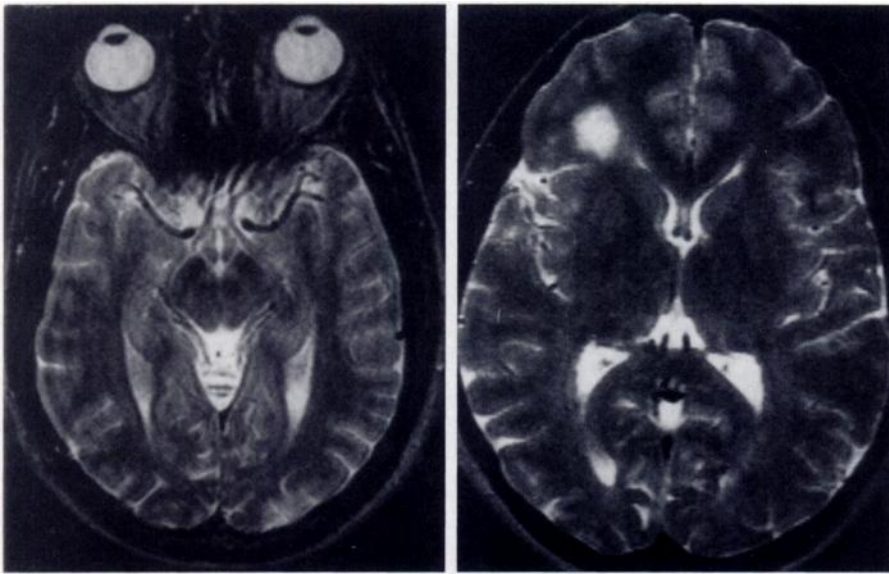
GRASE MR images obtained in the head with NSA = 1, image time of 36 seconds, and pulse sequence of 4,000/104. (a) Image obtained in healthy volunteer and (b) image obtained in a patient with multiple sclerosis. The image quality and S/N can be compared with those of brain images obtained with NSA = 2 in Figure 5, which were otherwise acquired with identical image parameters.
